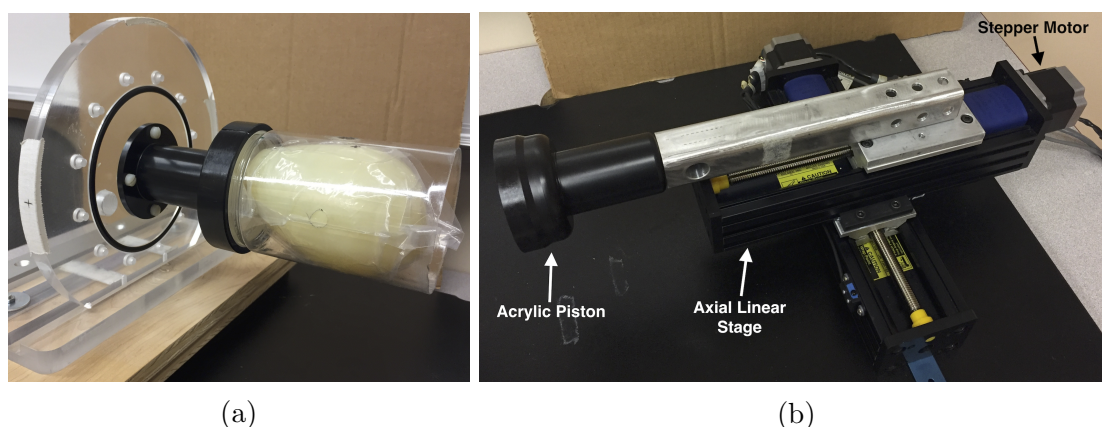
(a) Deformable gel dosimeter setup in 1 L plastic jar for irradiation and CT imaging and (b) an acrylic piston attached to a linear stage which is driven by a two-phase stepper motor for deformation of the gel in the axial direction.
